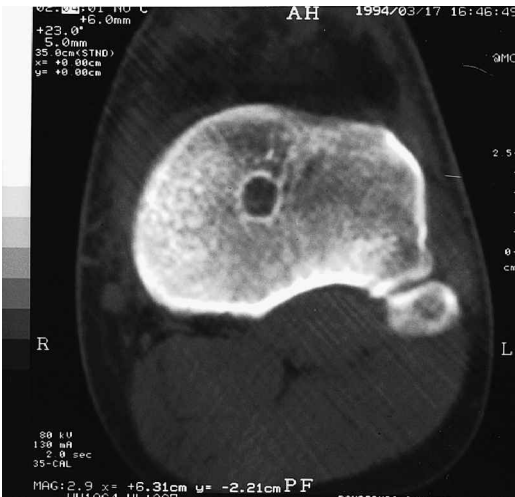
CT examinations in a given patient immediately after surgery (left) and again 13 months later (right). Note the dense, high attenuating zone lining the bone tunnel at 13 months.
